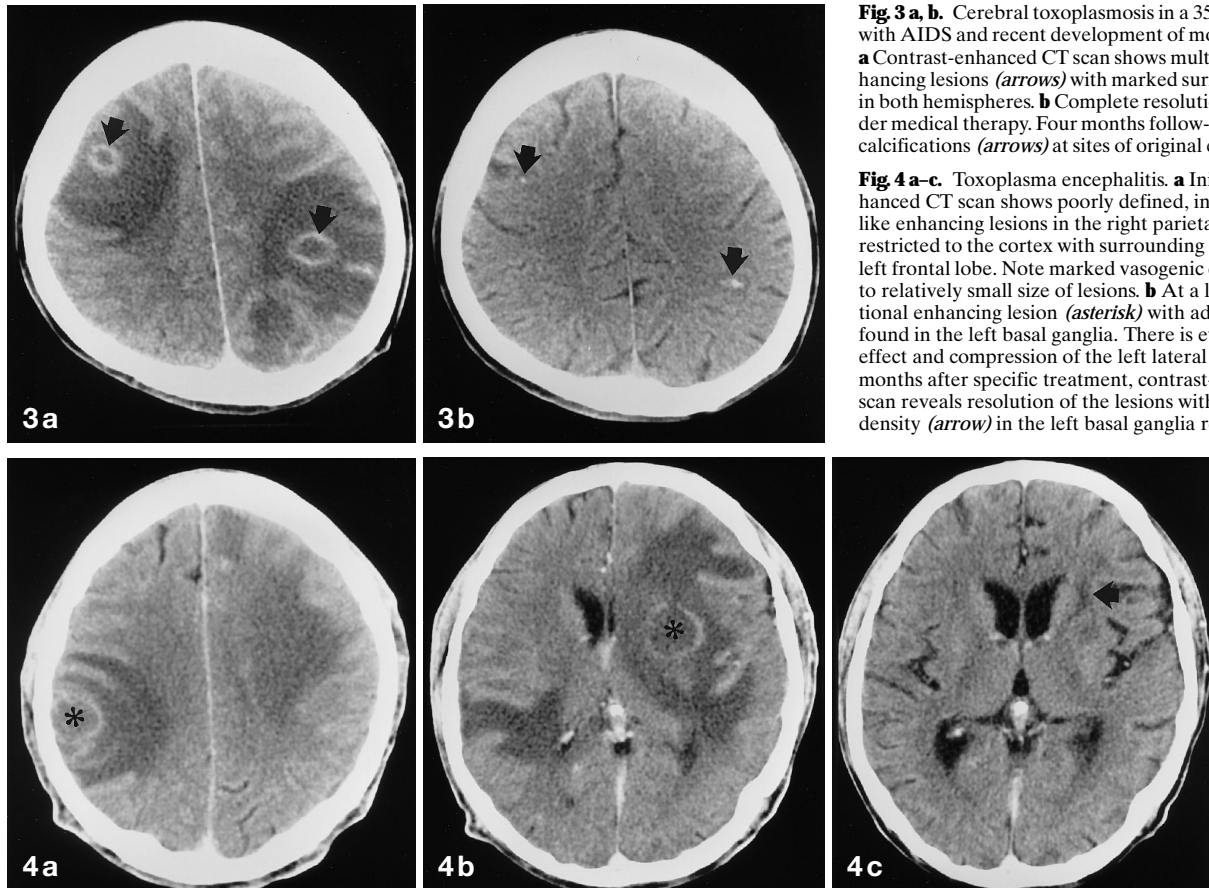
a, b. Cerebral toxoplasmosis in a 35-year-old man with AIDS and recent development of motor weakness. a Contrast-enhanced CT scan shows multiple ring-like enhancing lesions (arrows) with marked surrounding edema in both hemispheres. b Complete resolution of lesions under medical therapy. Four months follow-up CT scan shows calcifications (arrows) at sites of original enhancement
